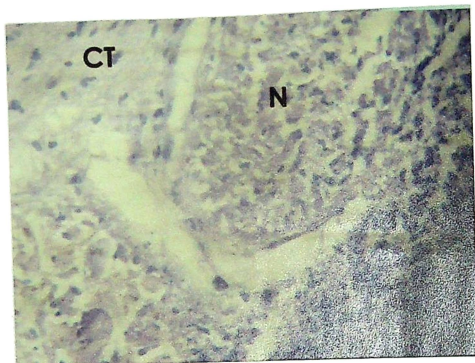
Area consisting of necrotic debris (N) walled off by lymphocytes (I) and fibroblasts (CT) in tumor treated for 72 hours (400X).
